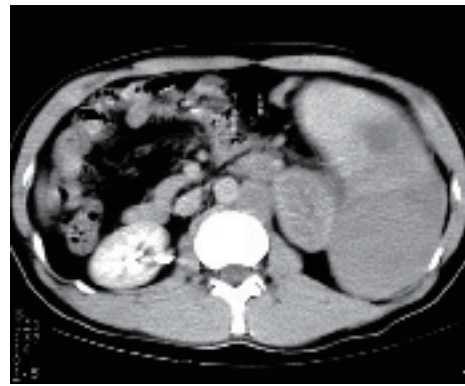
Enhanced CT showing multiple, homogeneous density, enlarged lymph nodes in para-abdominal aorta and multiple, low-density lesions in the spleen (splenic lymphoma).
